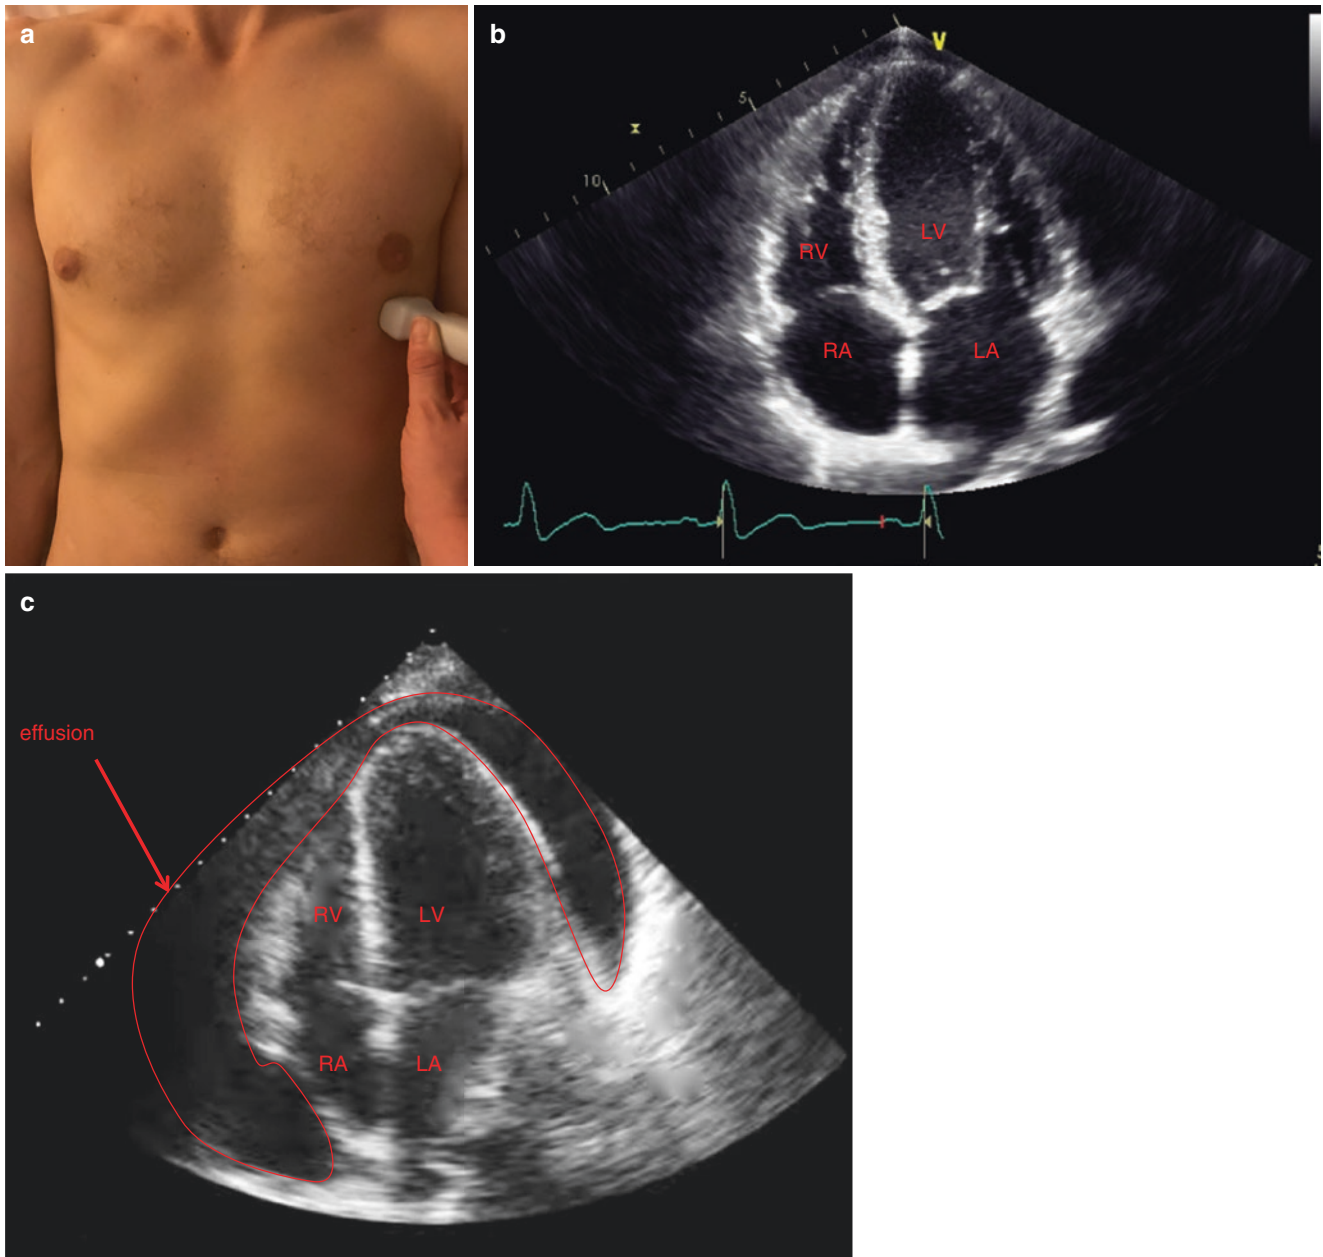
(a) Apical probe position. (b) Normal ultrasound image apical four-chamber view. (c) Apical view with pericardial effusion
